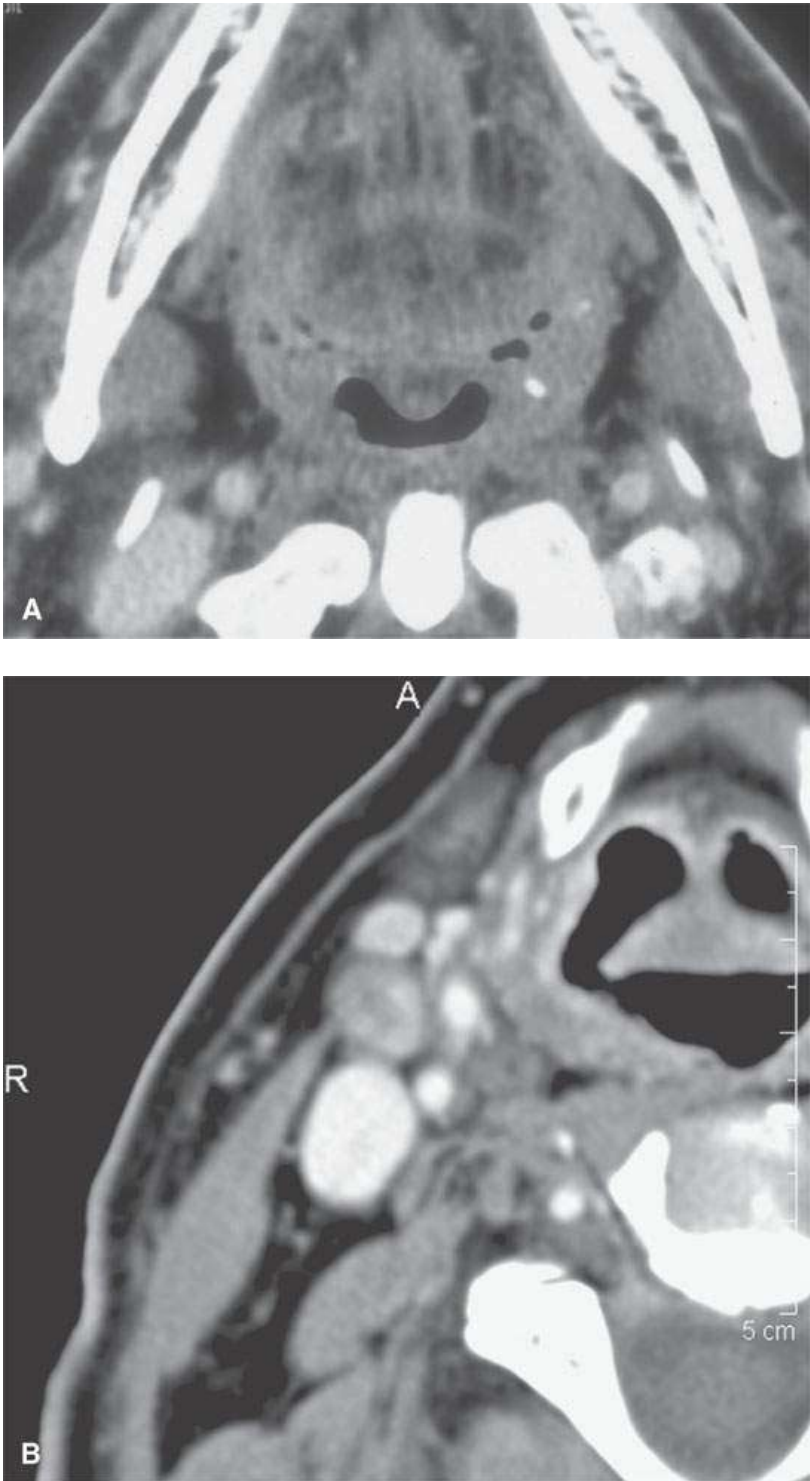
Examples of keratin and other “debris” mimicking calcification. A: Contrast-enhanced computed tomography (CECT) of normal variant of impacted high-density foci of material in tonsillar crypts. B: CECT of nodes surgically proven to contain high-density keratin debris and no calcification following radiotherapy.
